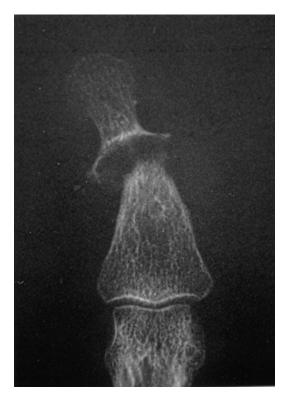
X-ray image of psoriasis at the distal interphalangeal joint
